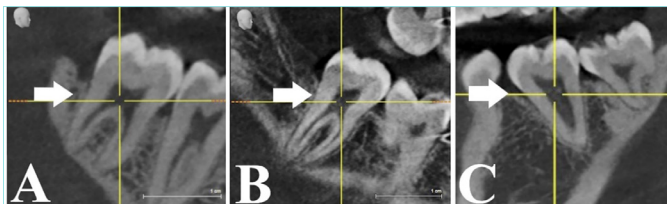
Representative sagittal CBCT sections demonstrating the mandibular molar (white arrow) exhibiting hypotaurodontism (A), mesotaurodontism (B), and pyramidal morphology (C), as observed in the present study.
